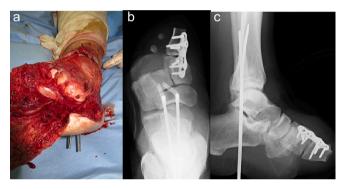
a: appearance after peroneus brevis tendon reconstruction (peroneous brevis tendon to the cuboid bone). b: A-P X-ray of the foot after fixation of Lisfaranc joint. c: lateal X-ray of the ankle.
